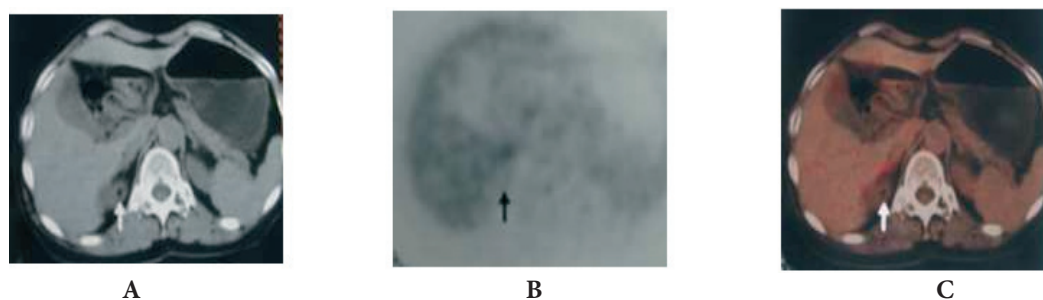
57-year-old man with lung squamous cell carcinoma was a true-negative case confirmed by clinical follow-up. A. An unenhanced CT scan shows a soft-tissue mass with low-attenuation area (white arrow) on the right adrenal gland. B. PET shows no abnormal uptake (black arrow) in the region of the right adrenal gland. C. Integrated PET/CT shows the soft-tissue mass has no abnormal uptake (white arrow) on the right adrenal gland.
